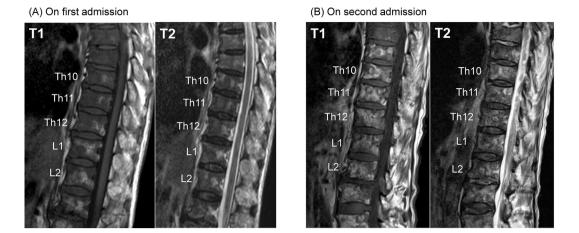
Magnetic resonance imaging of the vertebrae. T1-and T2-low-intensity lesions were found at vertebral bodies on admission (A). The findings exacerbated, showing spotted appearance on second admission (B).
